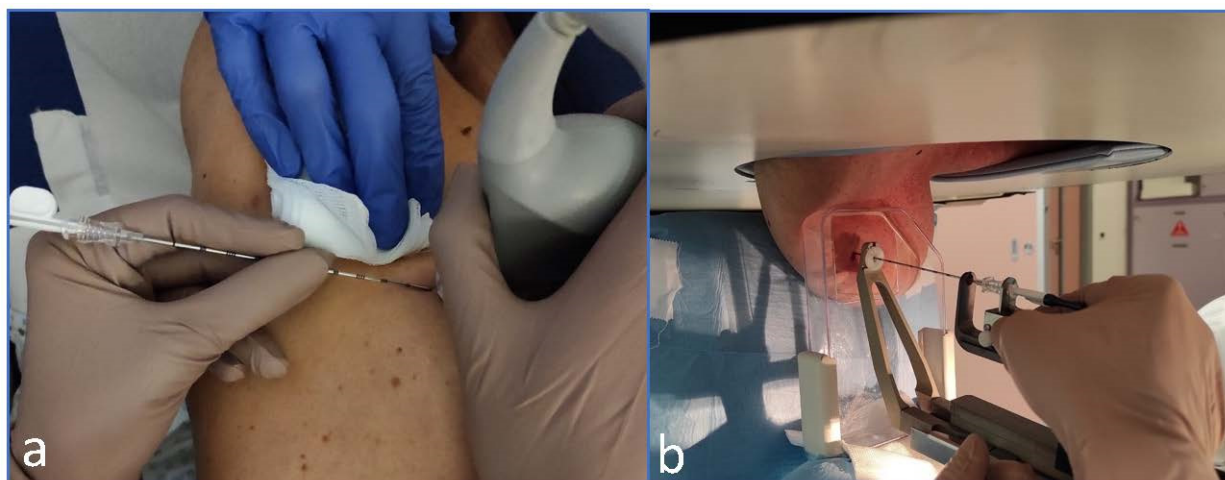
Magseed insertion: ultrasound (a) and stereotactic guidance (b).
